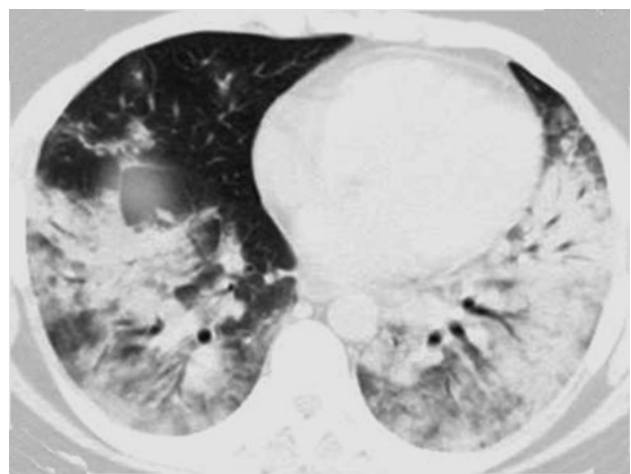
A 28-year-old woman with influenza A (H1N1) virus-associated pneumonia and diffuse alveolar hemorrhage. High-resolution computed tomography exhibits consolidations and ground-glass opacities in both lower lobes
